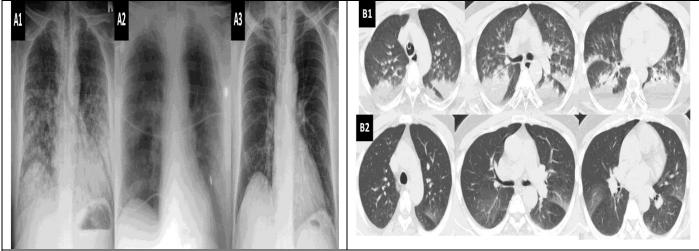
4th patient in the table: Bilateral air space consolidation (non-cardiogenic pulmonary edema) and ground glass opacities and daily (1st and 2nd) response to treatment were seen in figure 3A. HRCT images (bilateral air space and ground glass opacities) at hospital admission and response to treatment were seen in figure 3B.
